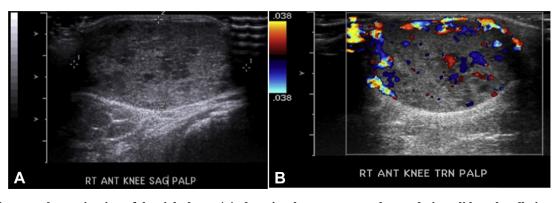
Ultrasound examination of the right knee. (A) There is a heterogeneous, hypoechoic, solid, and well-circumscribed mass corresponding to the patient's palpable complaint measuring $2.3 \times 2.7 \times 1.4$ cm. (B) Color Doppler shows extensive vascular flow within the lesion.
